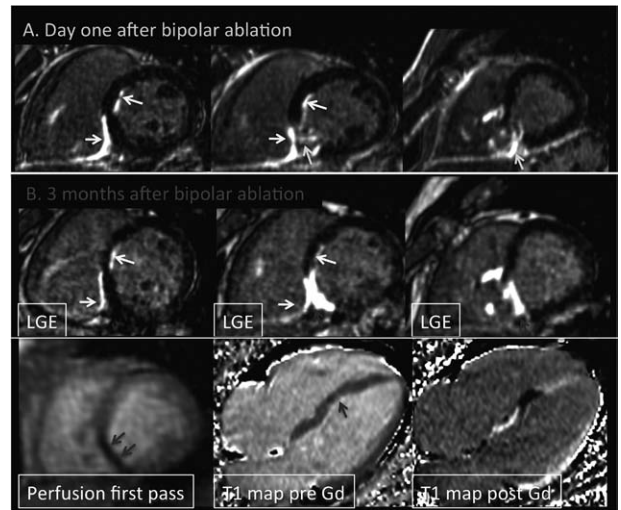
MRI data after bipolar ablation (seventh procedure). A, LGE images on day 1 after bipolar ablation show myocardial swelling and transmurals heterogeneous enhancement on the interventricular septum at the midventricular and apical levels (green arrows). B, LGE images 3 months after bipolar ablation show myocardial thinning and intense transmurals enhancement on the interventricular septum (top, blue arrows). First-pass perfusion imaging demonstrates severe microvascular dysfunction in the same area (bottom left, blue arrows). Myocardial T1 mapping before and after gadolinium administration indicates very dense scarring, with a calculated extracellular volume fraction of 85% (bottom center and bottom right, blue arrows). LGE indicates late gadolinium enhancement.
